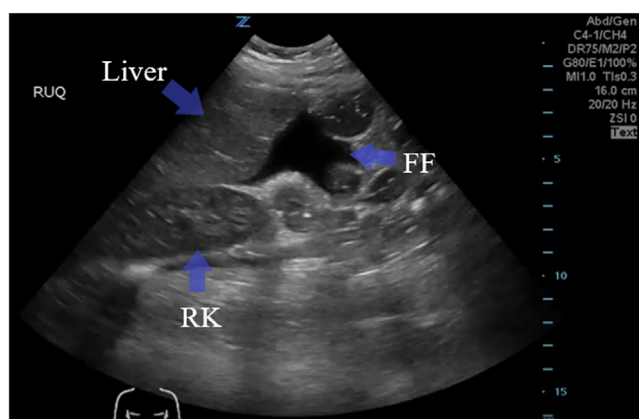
Right upper quadrant (RUQ) ultrasound view showing free fluid (FF)
